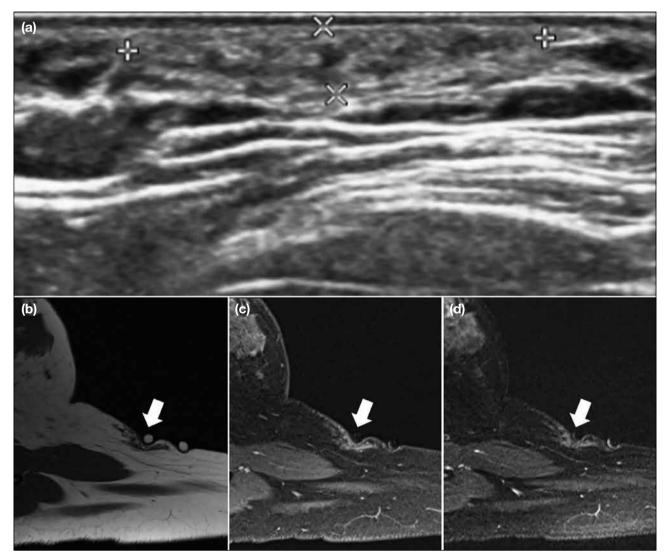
A 21-year-old female presented with a painful left axillary nodule. (a) Targeted ultrasound (US) shows a heterogeneous hyperechoic lesion at the left axilla similar to glandular breast tissue. (b-d) Magnetic resonance imaging (MRI) was subsequently performed as the US findings did not account for the clinical symptoms of significant pain. Axial T1-weighted (b), T2-weighted (c), and post-contrast T1-weighted MRI (d) of the left axilla showed a subcutaneous lesion with tissue signal identical to the left breast glandular tissue on all phases (arrows), consistent with accessory breast tissue.
